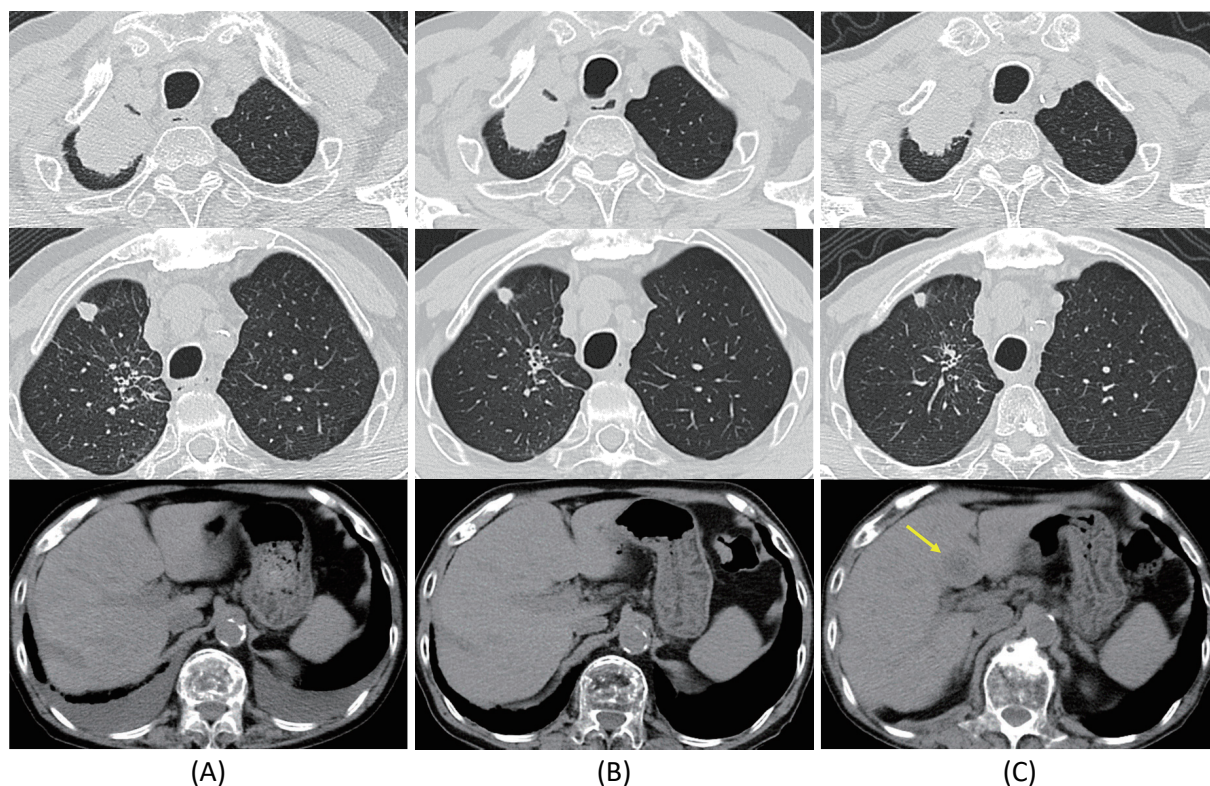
Chest CT findings of NSCLC. A: At the diagnosis, the images showed a mass in the right lung apex, a small nodule in the right upper lobe, bilateral pleural effusion. B: Three months after the initiation of osimertinib, the images showed a reduction in the size of the primary lesion and lung metastasis and resolution of the bilateral pleural effusion. C: Six months after the initiation of osimertinib, the primary lesion and lung metastasis presented at the time of diagnosis continued to decrease in size, but new liver metastases were observed (yellow arrow). CT: computed tomography, NSCLC: non-small cell lung cancer.
